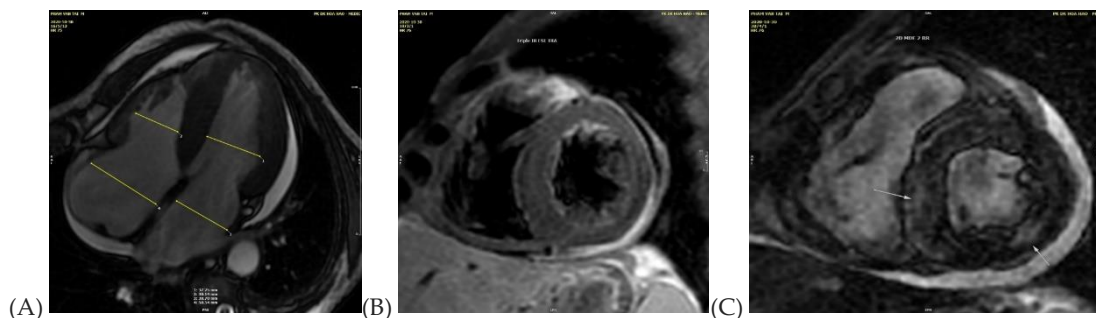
A: Cine MRI sequence showed biatrial enlargement, LV hypertrophy and small pericardial effusion. B: Dark blood and Fat-sat or Triple IR FSE T2 demonstrated the myocardial hyper-signal, especially subendocardial area. C: Myocardial nulling technique used to null the signal from normal myocardium during delayed-enhanced imaging; the LGE was diffuse in myocardium.
